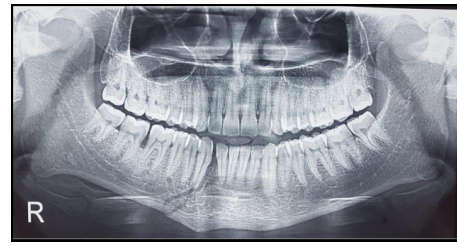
Pre-operative orthopantomogram revealing right parasymphysis fracture
